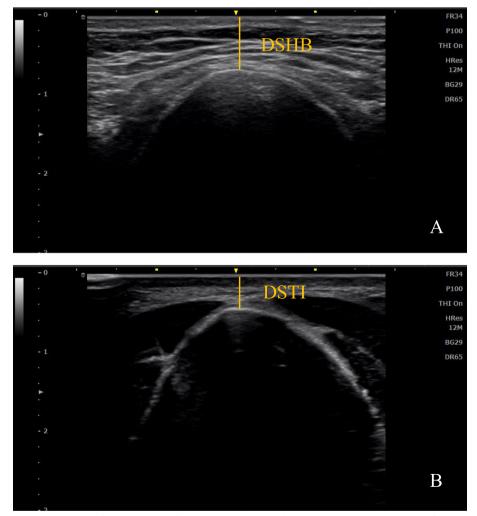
Ultrasonographic measurement of (A) the distance from the skin to the hyoid bone (DSHB) and (B) the distance from the skin to the thyroid isthmus (DSTI)
